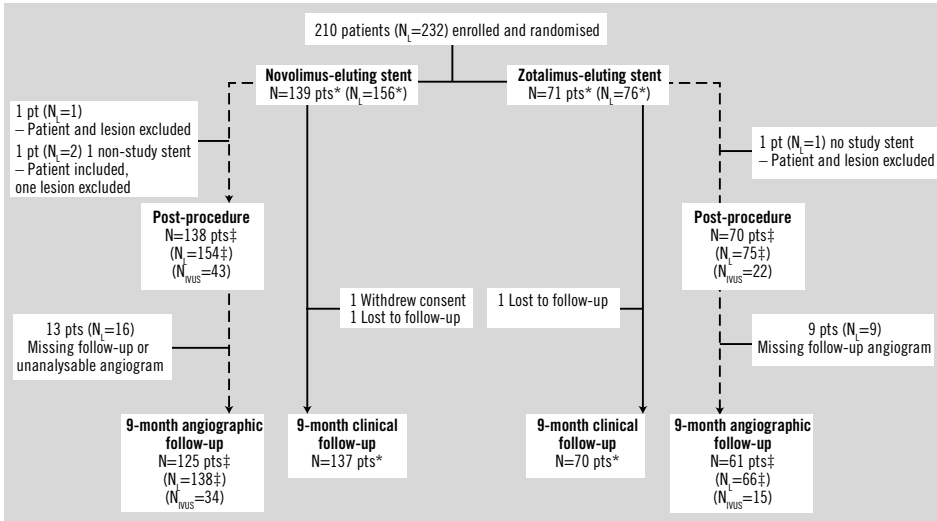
Clinical and angiographic follow up of patient population. Pts: patients; N_L: number of lesions; IVUS: intra-vascular ultrasound; *Intention to treat analysis; ‡ Modified intention to treat: lesions with at least 1 study stent
